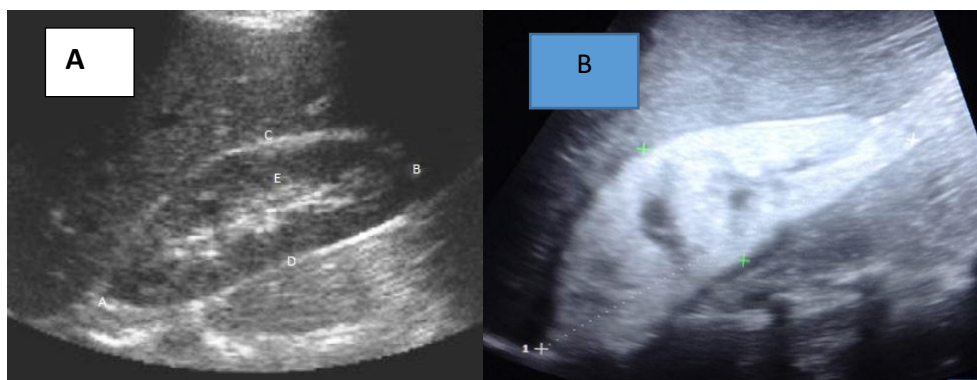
Shows a gray scale ultrasound image of a left kidney with normal echogenicity [A] and echogenic left kidney in a 42-year-old HIV positive man [B]
